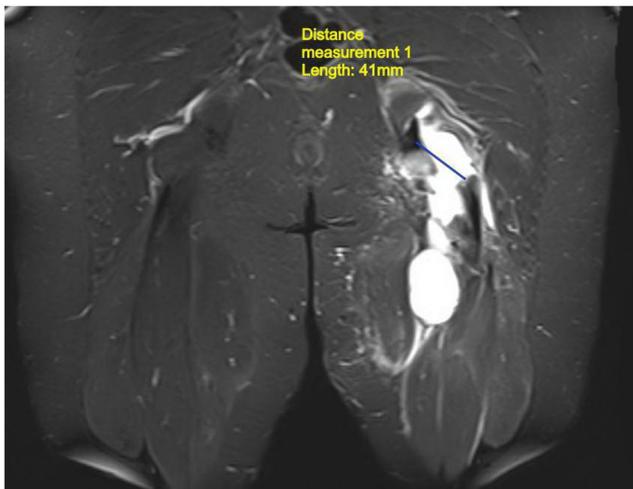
Coronal T2-weighted MRI demonstrating a complete proximal avulsion injury with 4 cm of distal retraction
